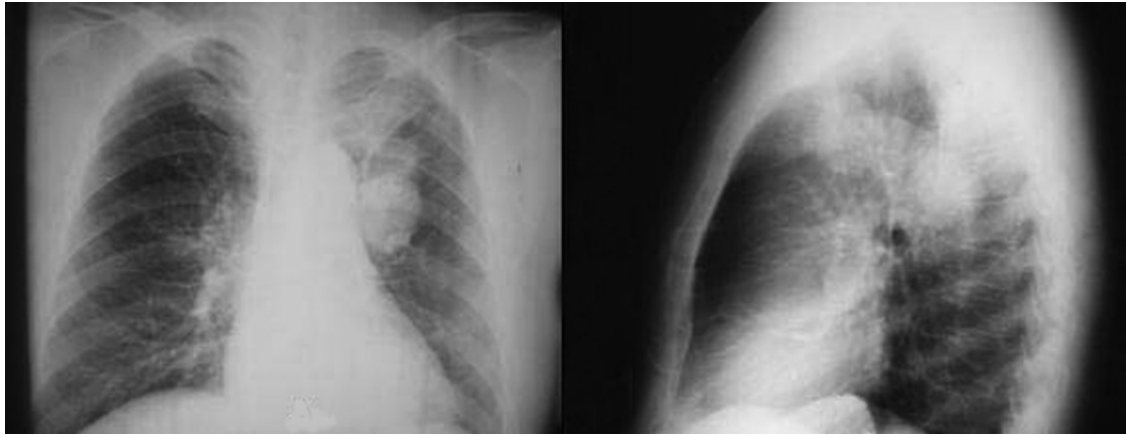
Chest radiograph demonstrating 2 similar zone masses located on the 2 segments of the left upper lobe in patient 3.
